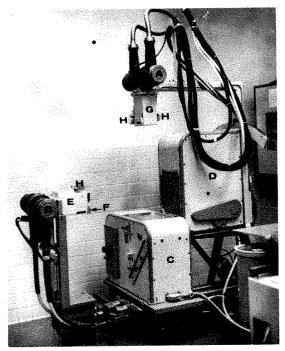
Apparatus arranged for left sided angiography. A. Frontal x-ray tube. (Arms shown with frontal beam at 90° to frontal film. By means of a pivot, lying in the plane of the frontal film, the beam may be angled in either direction away from the perpendicular.) B. Lateral tube with its beam centered at center of lateral film (it may be shifted slightly above or below center). C. Frontal changer (shown in its normal position in contact with lateral changer). D. Lateral changer. E. Beam collimator on lateral tube. F. Lever for operation of 5 inch by 5 inch stop. G. Collimator on frontal tube. H. Light localizers. (They cast bright cross marks defining centers of the two beams.) I. Transformers supplying 6 volts A.C. to localizer lamps.
